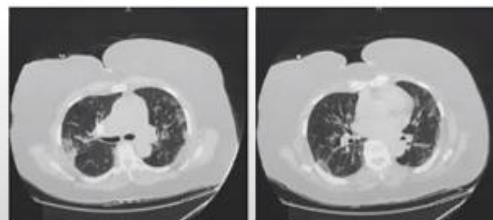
CT chest showing patchy subpleural ground-glass opacities compatible with atypical/viral pneumonia. The patient also had a positive COVID test.
